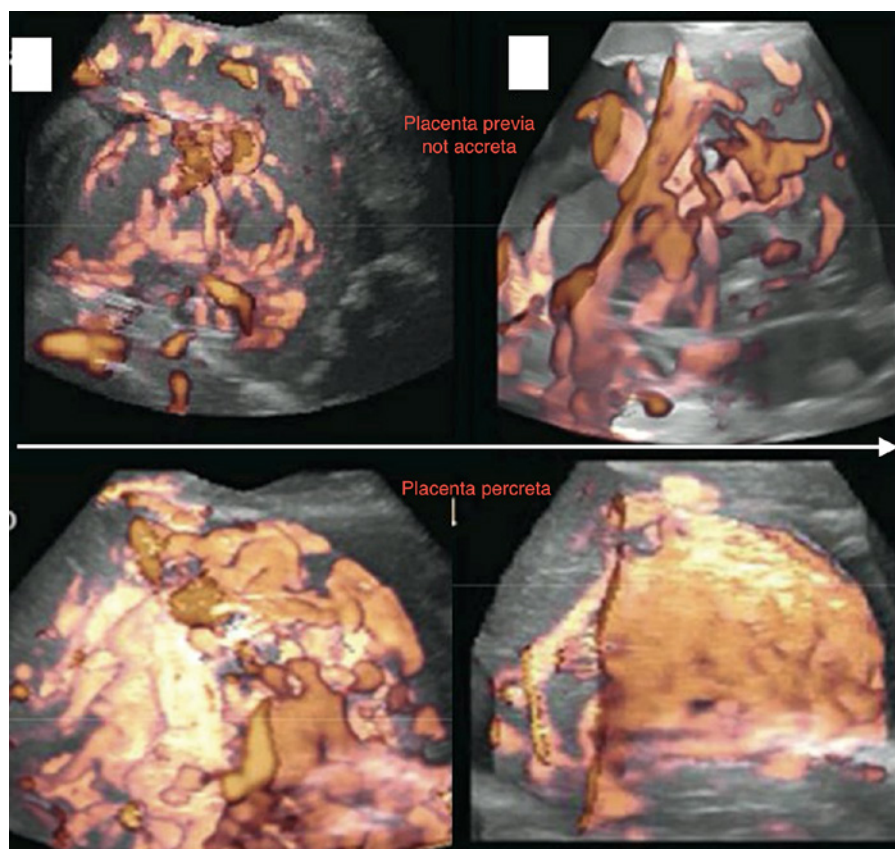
Placenta *percreta*: 3D color ultrasound shows increased vascularity of the uterine serosa/bladder interface.
